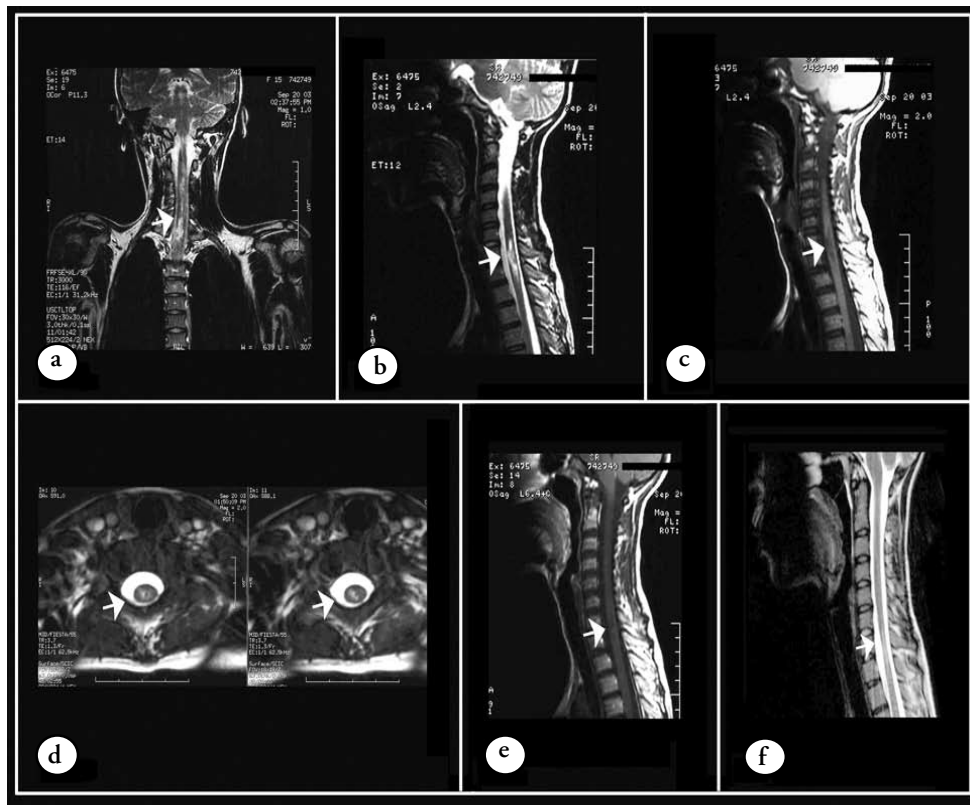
Spinal cord MRI a, b, d) sagittal and axial T2 weighted images showing the extended T2 hyperintensity segment in acute cervical myelitis (arrows). c) T1 weighted image showing the myelomalacia (arrow). e) Gadolinium-enhanced T1 weighted image showing faint enhancement (arrow) f) T2 weighted image, 2 years follow up study showing segmental T2 cervical cord hyperintensity and spinal atrophy (arrow).
